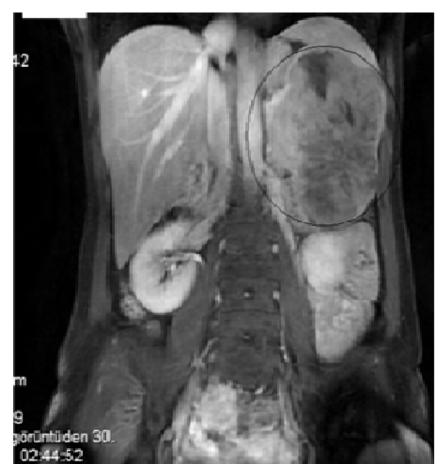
Contrast enhanced MRI showed a 16 cm sized heterogeneous lesion which had cystic necrotic areas
